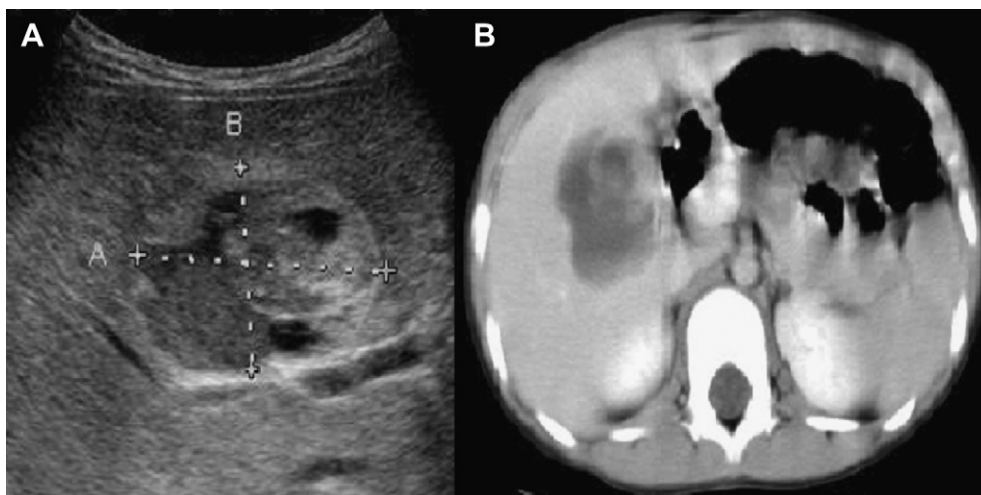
(A) Undifferentiated sarcoma, case 7: Large, heterogeneous cysts were separated by echogenic septation. (B) CT: A huge tumor including solid and cystic parts is located in the right lobe of the liver.
